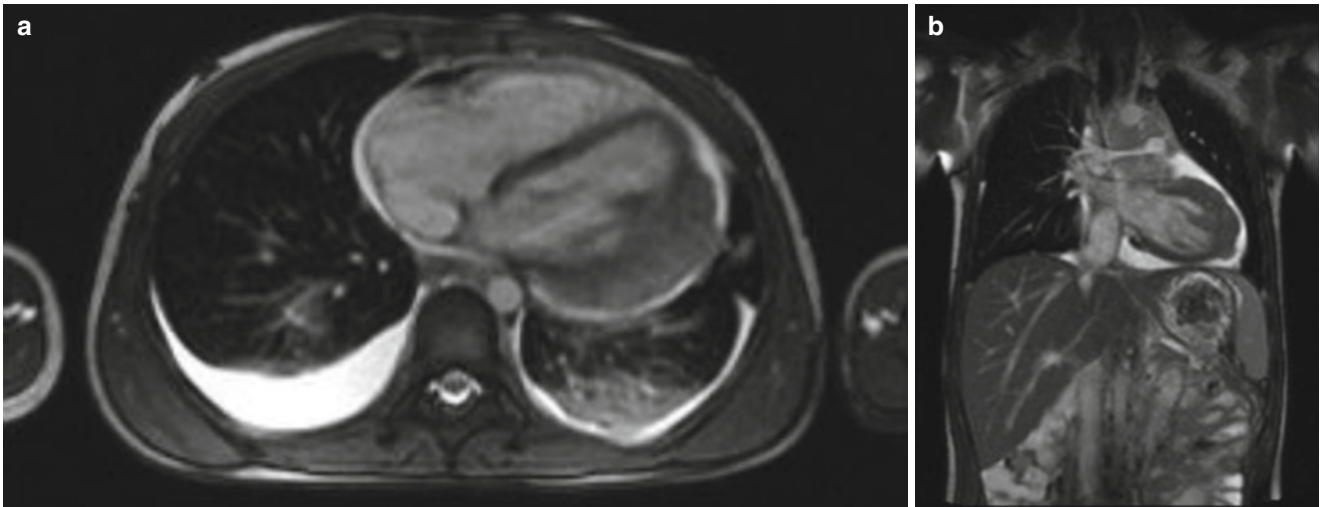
Cardiac Rhabdomyosarcoma. Axial (a) and coronal (b) single-shot balanced gradient echo MRI sequence through the thorax demonstrate a large exophytic mass arising from the free wall of the left lateral ventricle. There are pericardial and bilateral pleural effusions
